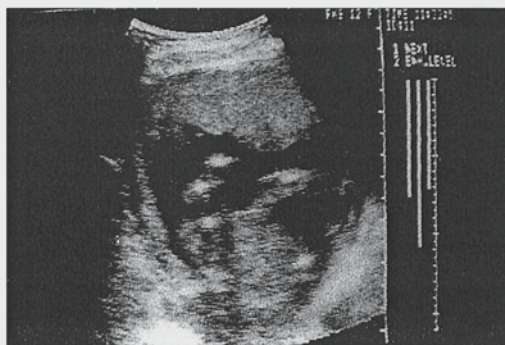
Ultrasonic tomographic image with its positional information superimposed.
